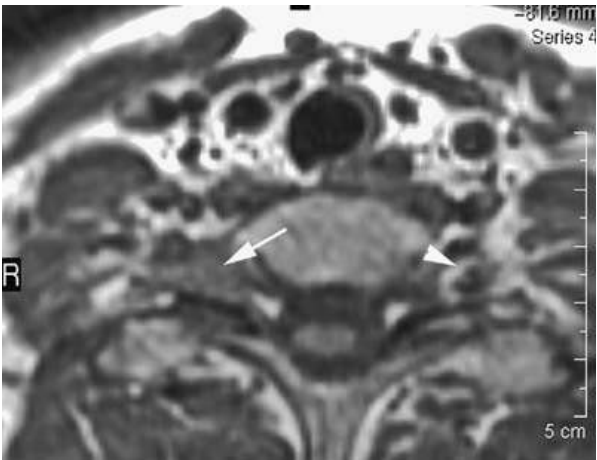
Magnetic resonance imaging of a child presenting with a neck mass believed to likely be rhabdomyosarcoma with biopsy revealing non-Hodgkin lymphoma. The transcompartmental mass (*arrows*) encases the carotid artery (*arrowheads*). A: T2-weighted image. B: Non-contrast-enhanced T1-weighted image.
